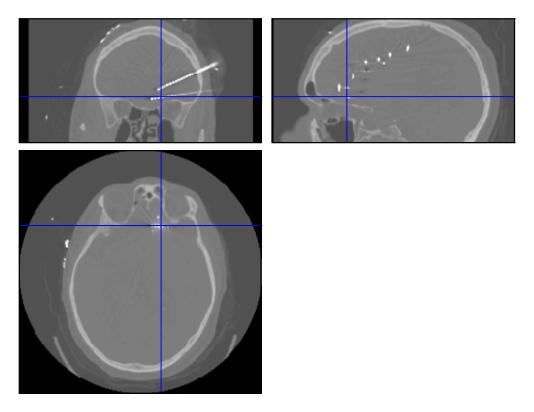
Coronal (top, left), sagittal (top, right) and axial (bottom) sections of the post-CT of a representative patient in SPM8. Crosshairs indicate a contact of a depth electrode implanted in the OFC.
